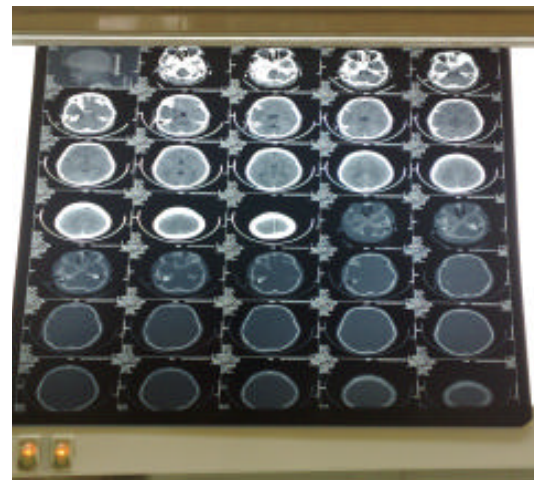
Patient's brain CT scan
